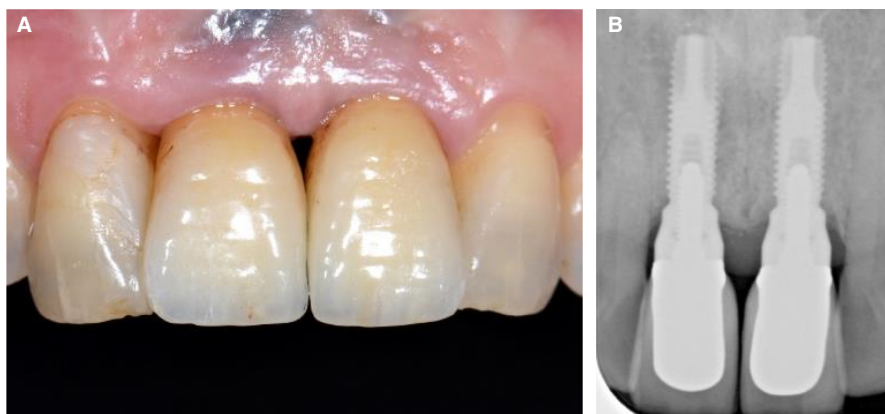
A, The papilla between the two implants in the maxillary right and left central incisor sites has flattened because of remodeling of the bone between the two implants. B, The corresponding periapical radiograph shows the flattening of the bone between the two implants. There is approximately 3.5 mm of soft tissue thickness over the interimplant peak of bone
